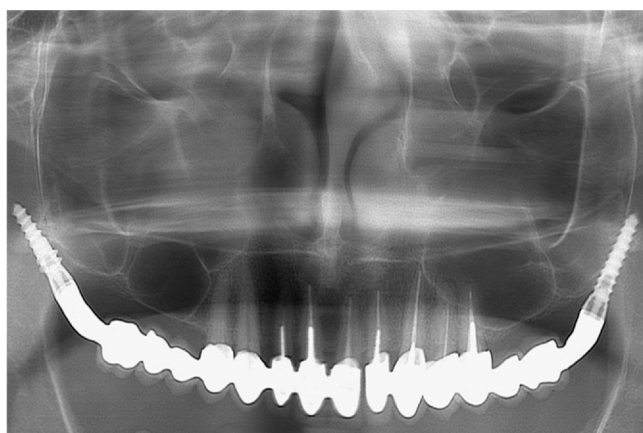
Panoramic radiograph showing maxillary prosthesis using natural dentition and 2 pterygoid implants placed in right and left posterior maxillary area, referred to as complete maxillary reconstruction on implants and teeth.
